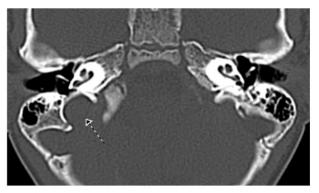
Axial CT cut bone window revealed prominent high riding right jugular bulb [arrow] reaching the level of the basal cochlear turn.
